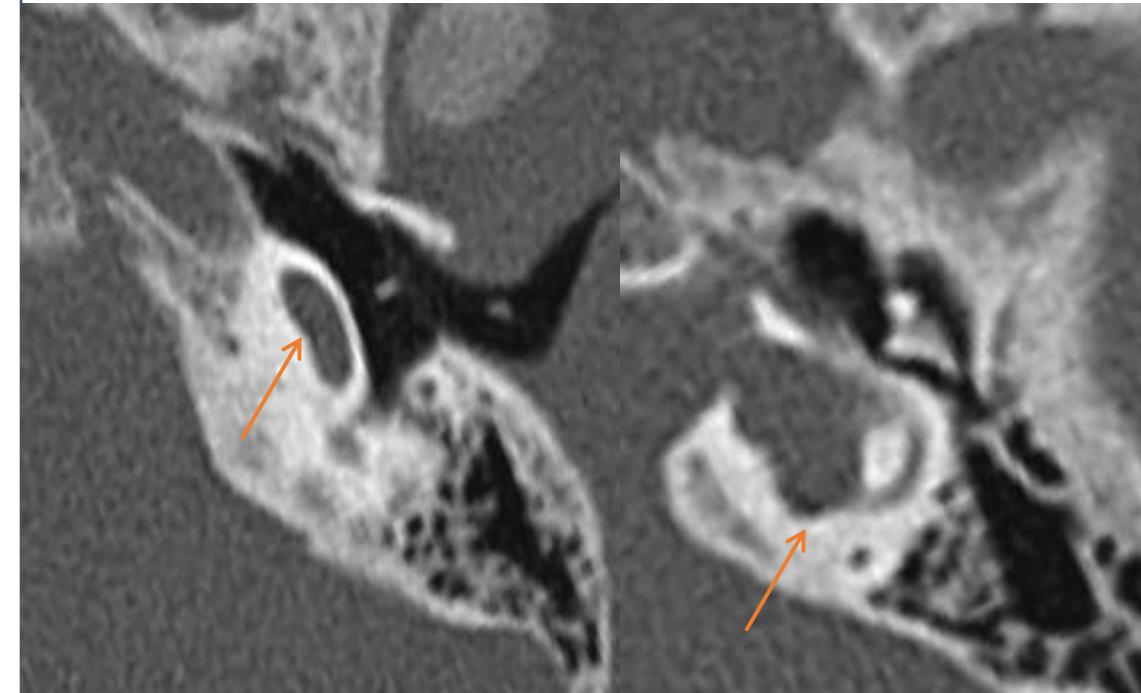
(a): CT- Cystic cochlea bilaterally with absent modiolus and interscalar septa, (Incomplete Partition, IP-1). Enlarged and dysplastic bilateral vestibule and enlarged IAC. 1(b)MRI – hypoplasia of cochlear nerves; good outcome.
